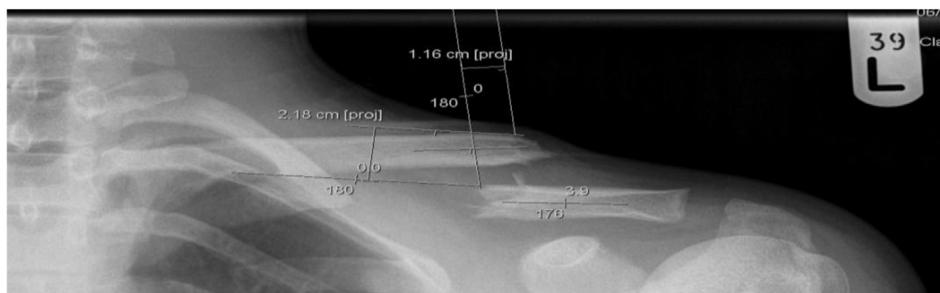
Example of Pre-op x-ray of patient in this study with lines drawn to measure shortening, displacement and angulation.
